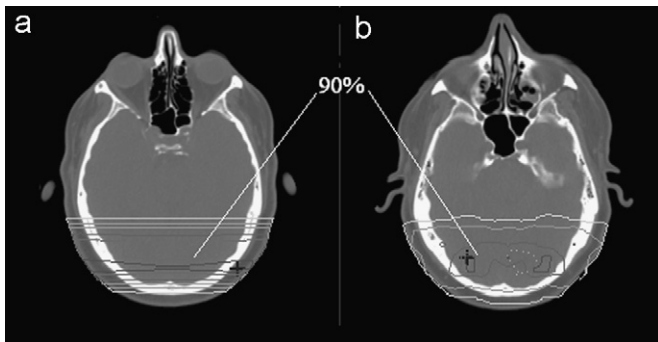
Isodose curves for normal tissue, calculated using (a) photon flux and (b) electron flux. The CT slice in each case corresponds to the location of the global maximum for normal tissue (cross), chosen as normalization value. 90% isodose reaches the skin in case (a), while it closes deeper in tissue in case (b).
